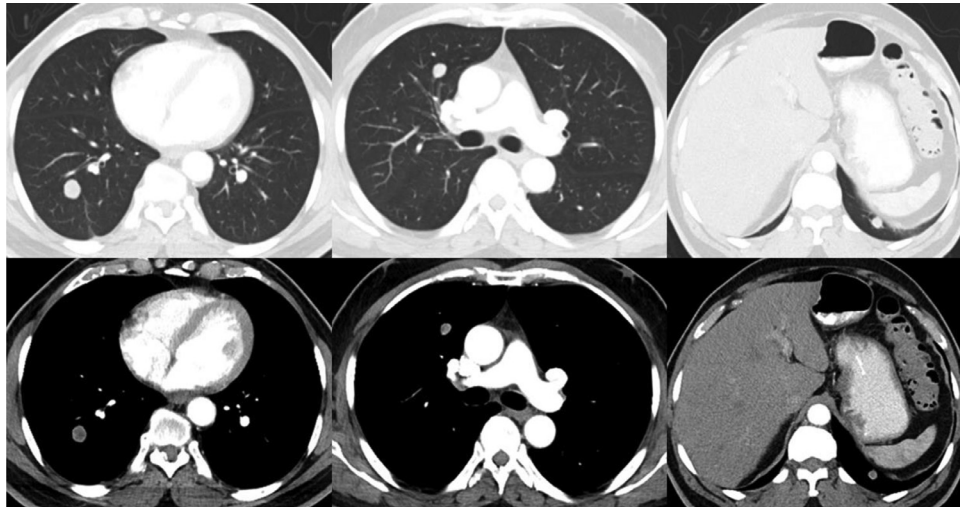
Contrast enhanced chest CT in lung and mediastinal windows shows multiple bilateral well-defined pulmonary nodules with peripheral enhancement.
